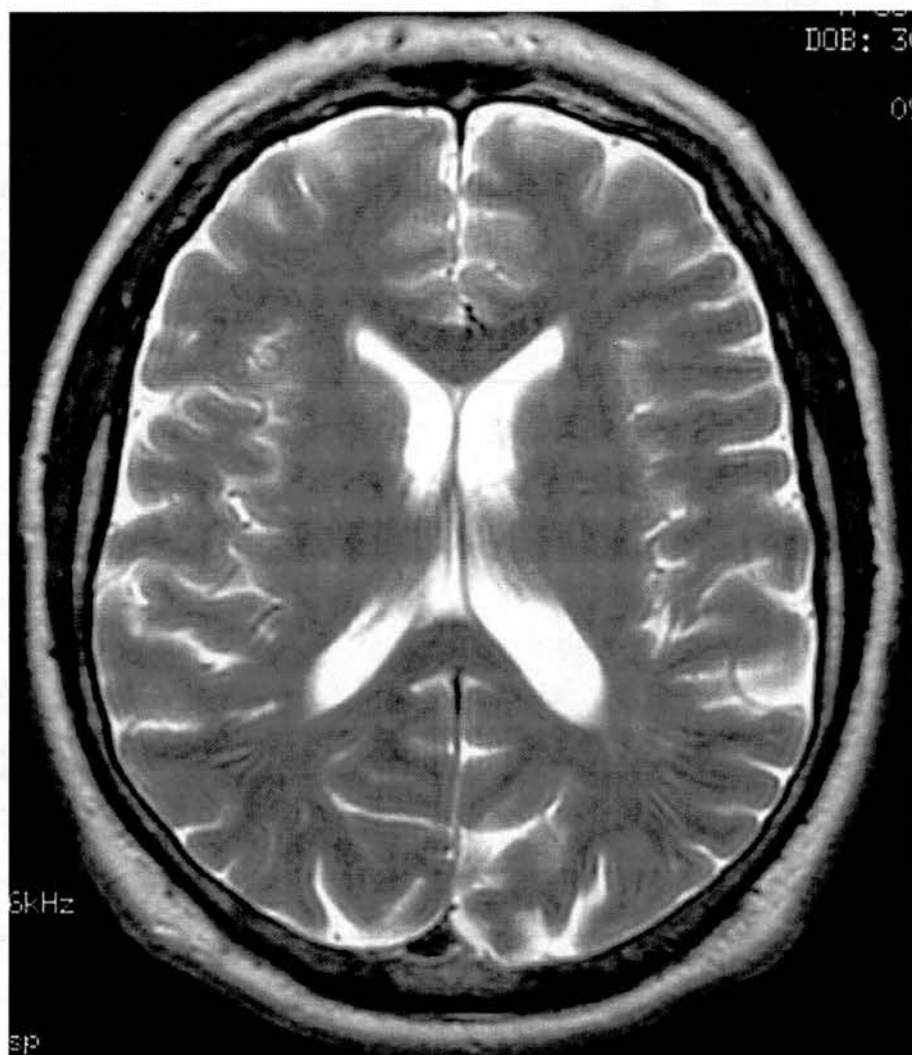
Cv. A T₂ MRI image of approximately the same slice. Note the superior soft-tissue discrimination.
